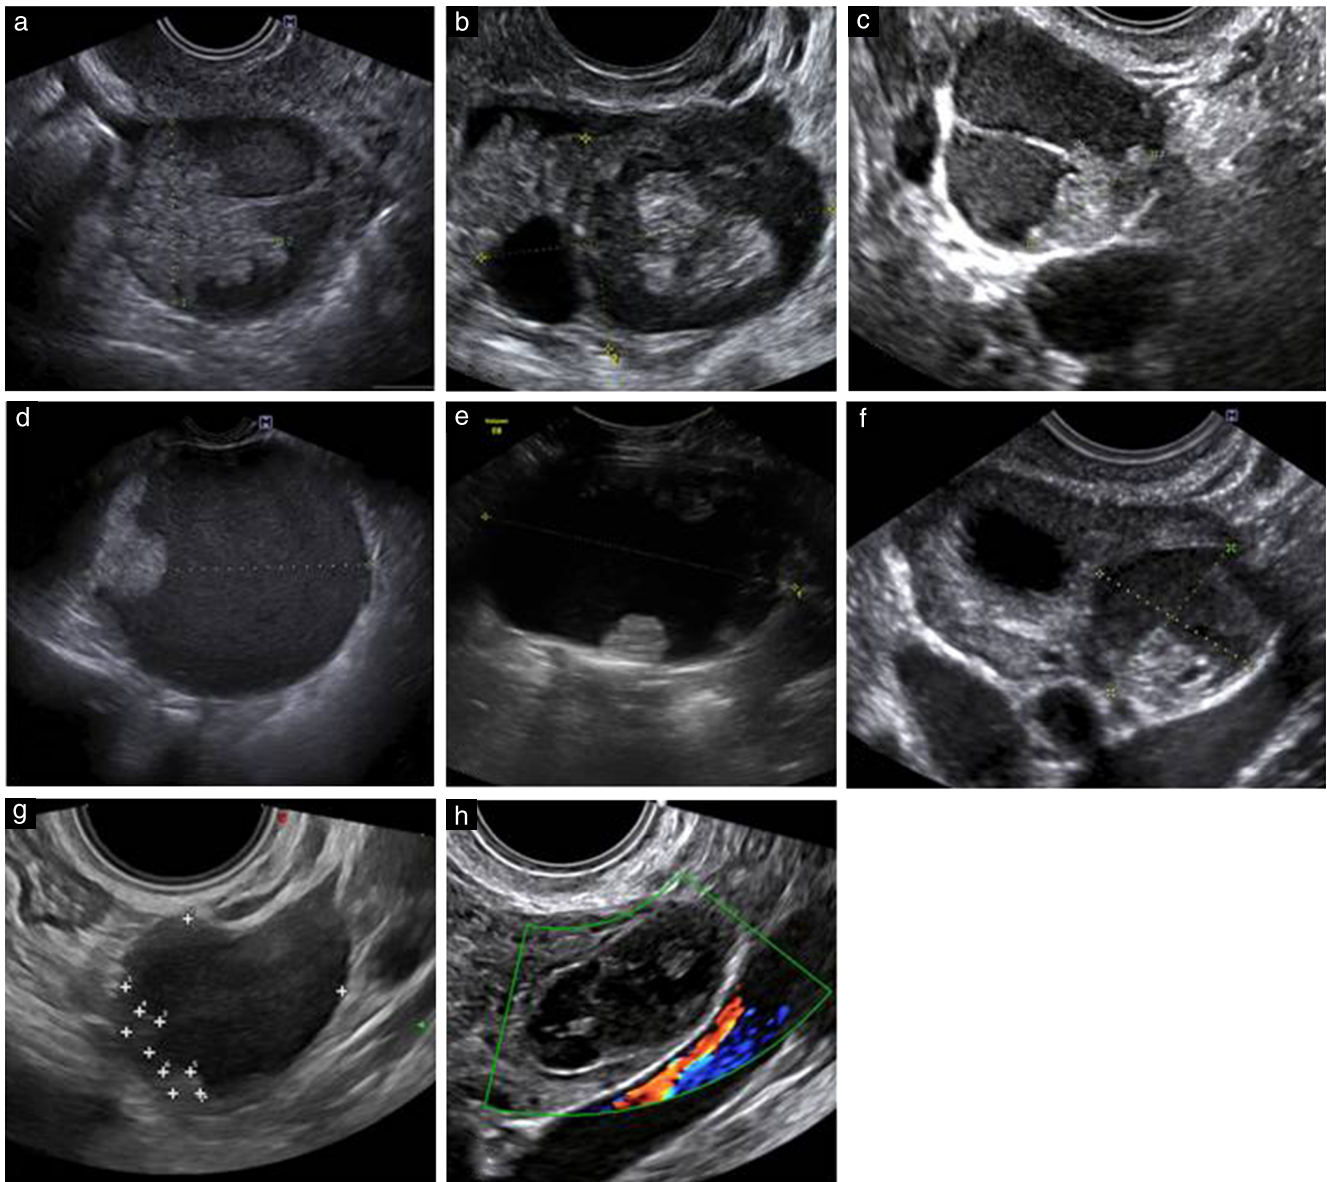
Ultrasound images of endocervical-type borderline ovarian tumors, presenting as multilocular-solid (a–d), unilocular-solid (e–g) or unilocular (h) cysts, the majority being multilocular-solid. Papillary projections are commonly noted (a,c–g). Lesions in (b–g) were diagnosed correctly by ultrasound examiner as borderline, mass in (a) was misdiagnosed as invasive and mass in (h) had uncertain diagnosis.
